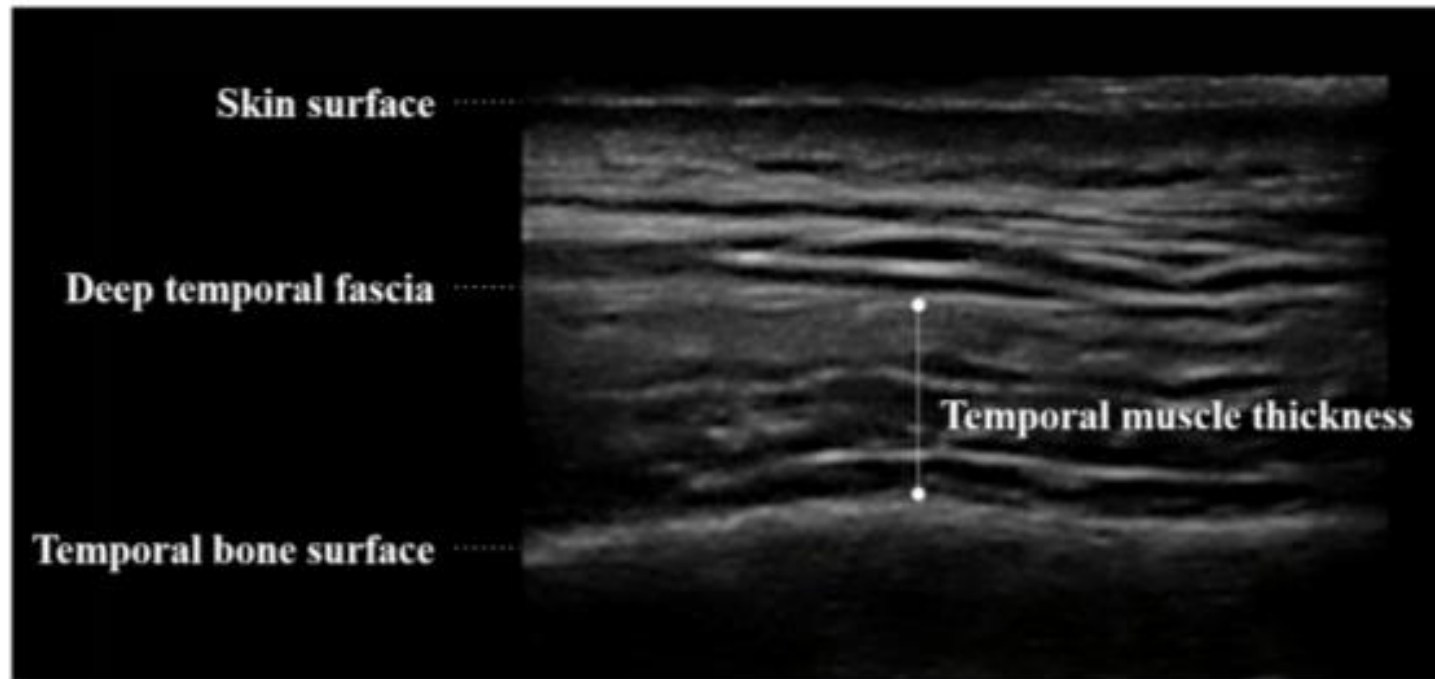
Ultrasonographic image of temporal muscle. Muscle thickness was defined as the distance between deep temporal fascia to the temporal bone surface. The exact location of measurement was defined upon agreement by three nursing researchers as the highest point in the skull surface in each image
